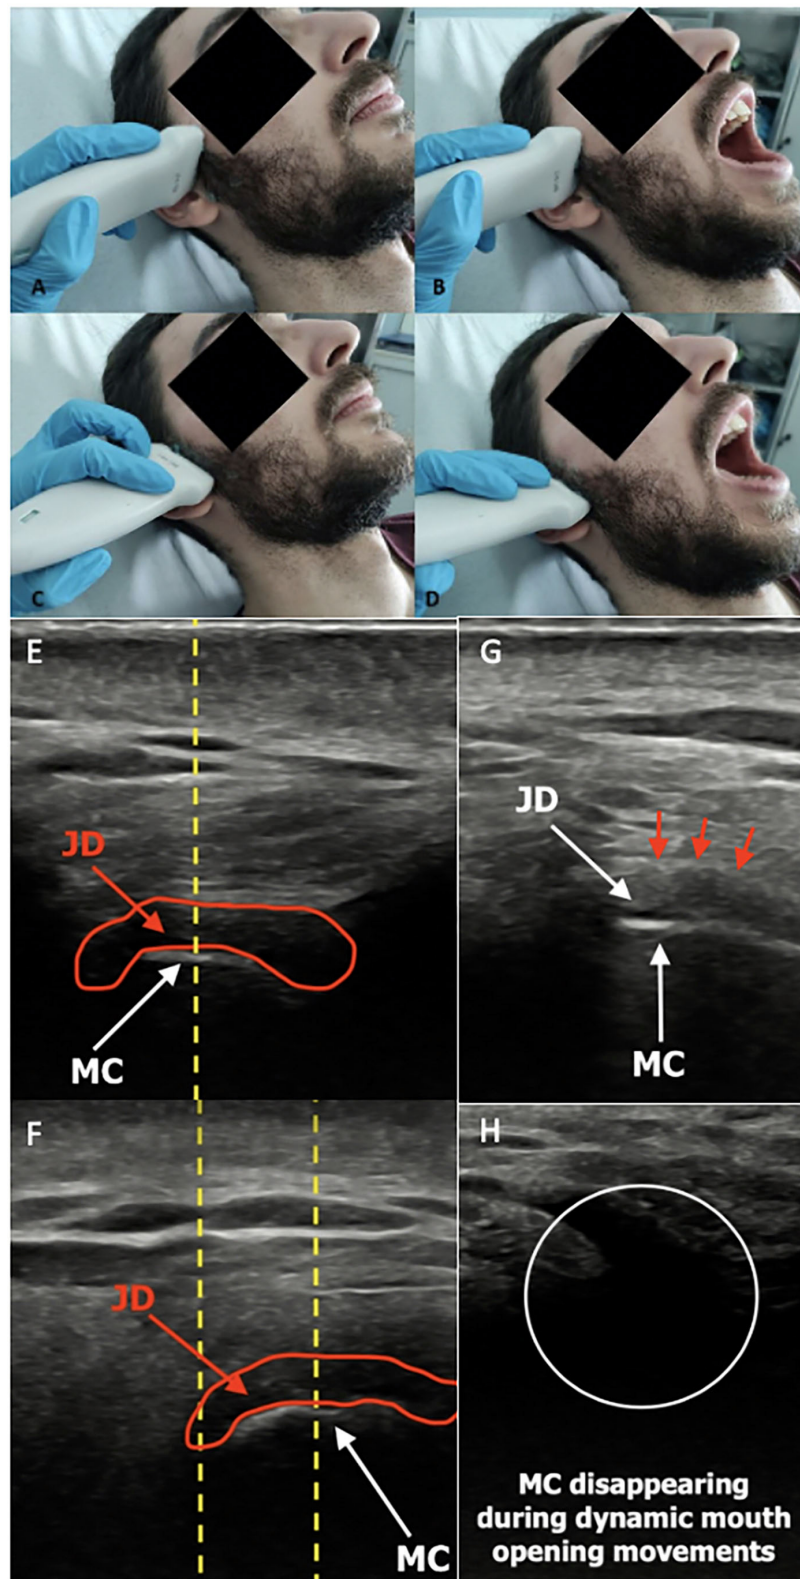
Conventional US transducer positions are parallel to the Frankfort horizontal plane (a plane connecting the highest point of the opening of the external auditory canal with the lowest point on the lower margin of the orbit) in closed-mouth (A) position and open-mouth (B) position, as well as parallel to the ramus of mandible, both in closed-mouth (C) and open-mouth (D) positions. Normal ultrasound image of TMJ in transverse sections in closed- (E) and open-mouth
